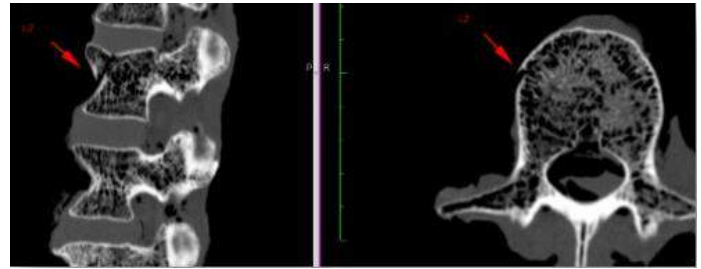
Posttest CT showing L2 vertebral body fracture
